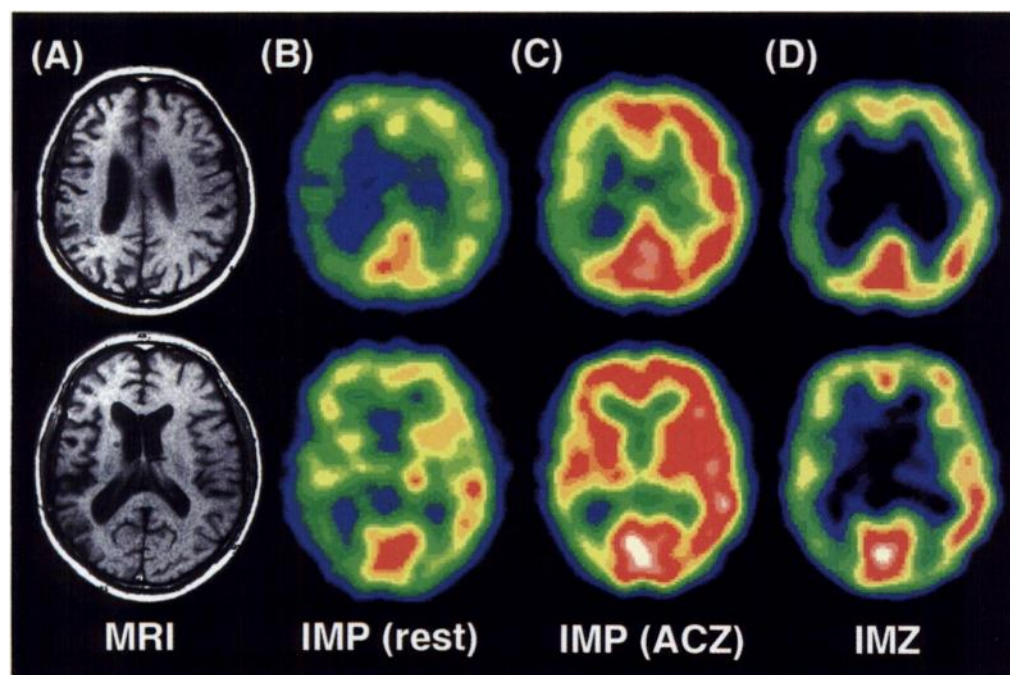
(A) MR and (B–D) SPECT images for Patient 11. (A) MRI demonstrated hemispheric atrophy of the right side with cortical infarction in the right temporal lobe. (B) Iodine-123-IMP SPECT in the resting state revealed a perfusion deficit in the infarcted area and low perfusion throughout the entire territory of the MCA. However, after (C) acetazolamide challenge, cerebral perfusion reserve in the right hemisphere was preserved, except in the infarcted area. (D) Iodine-123-iomazenil SPECT revealed low accumulation throughout the entire territory of the MCA on the right side, suggesting the presence of neuronal loss associated with cortical atrophy.
